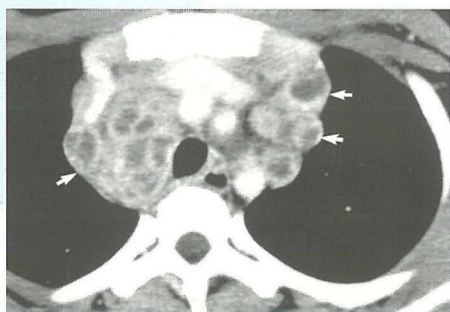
CT scan shows bilateral hilar TB lymphadenopathy.
